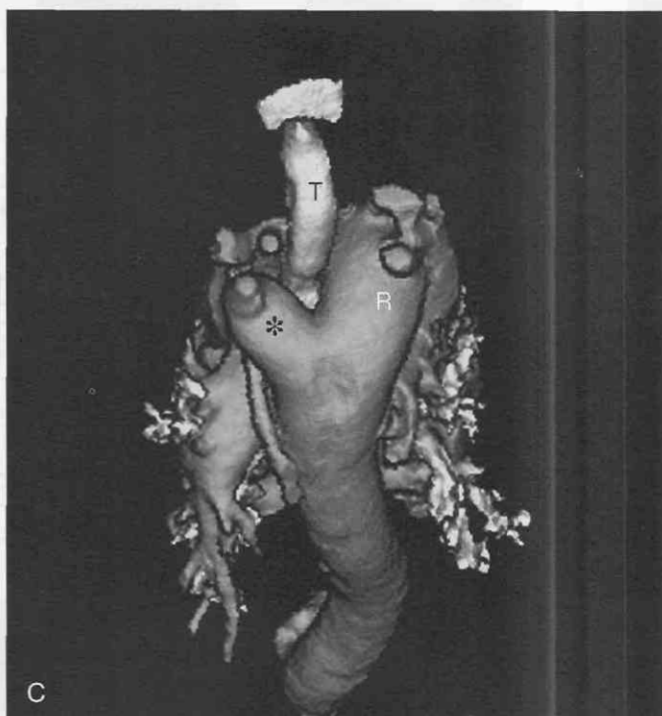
A, Axial CT scan demonstrates the right aortic arch with aberrant left subclavian artery (arrow). B, Coronal multiplanar reconstruction shows that the aberrant left subclavian artery (arrow) originates from an aortic diverticulum. C, Shaded surface display from a posterior perspective shows the right aortic arch (R) with the aberrant left subclavian artery (*). Note the relationship to the trachea (T).
